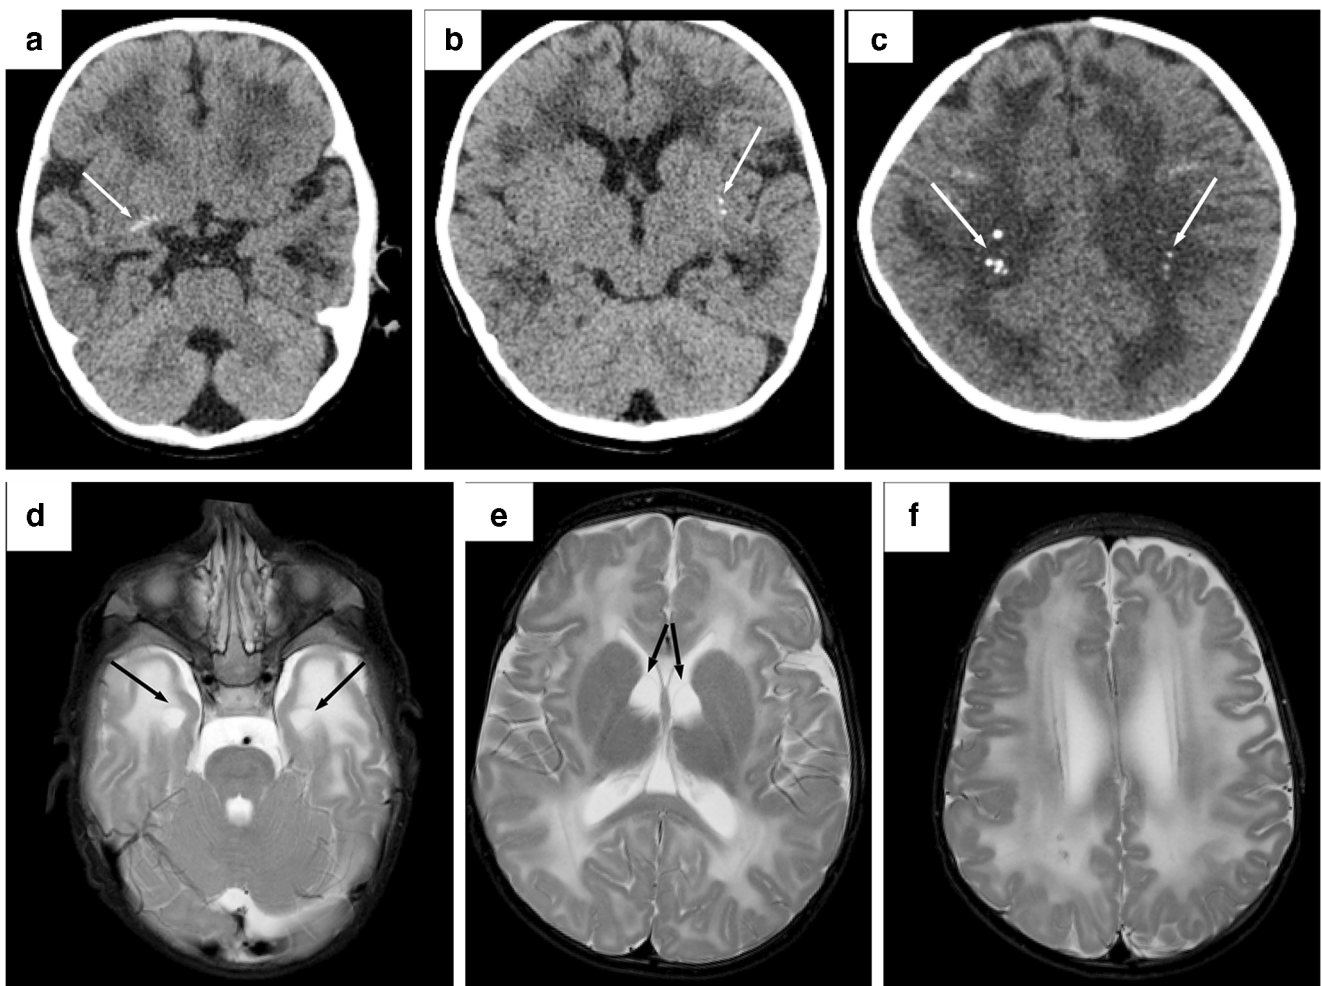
RNASET2* with global developmental delay in a 5-month-old boy. a, b Axial nonenhanced CT images show right (a) and left (b) basal ganglia calcification (*arrows*). c Axial nonenhanced CT image shows bilateral deep white matter calcification (*arrows*). d–f Axial T2-weighted MR images show extensive periventricular deep and subcortical
